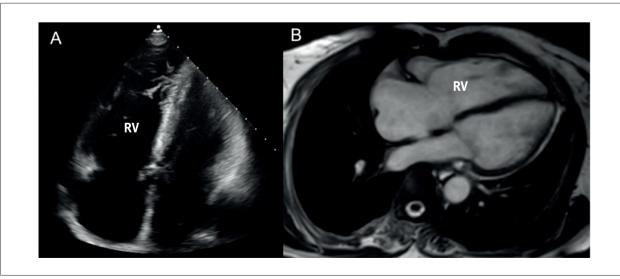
A) Apical four-chamber view on transthoracic echocardiogram showed right heart dilatation and reduced right ventricular systolic function. B) Cardiac magnetic resonance imaging disclosed the right heart dilatation, right ventricular dyssynchronous movement, and right ventricular systolic dysfunction (RV ejection fraction 30%). RV: right ventricle.
